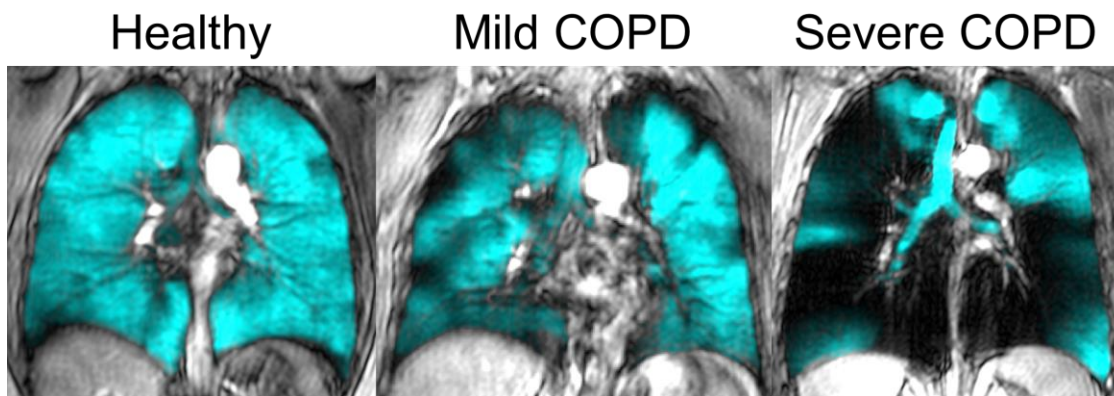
^3He hyperpolarized gas MRI for healthy, mild COPD and severe COPD individuals.
